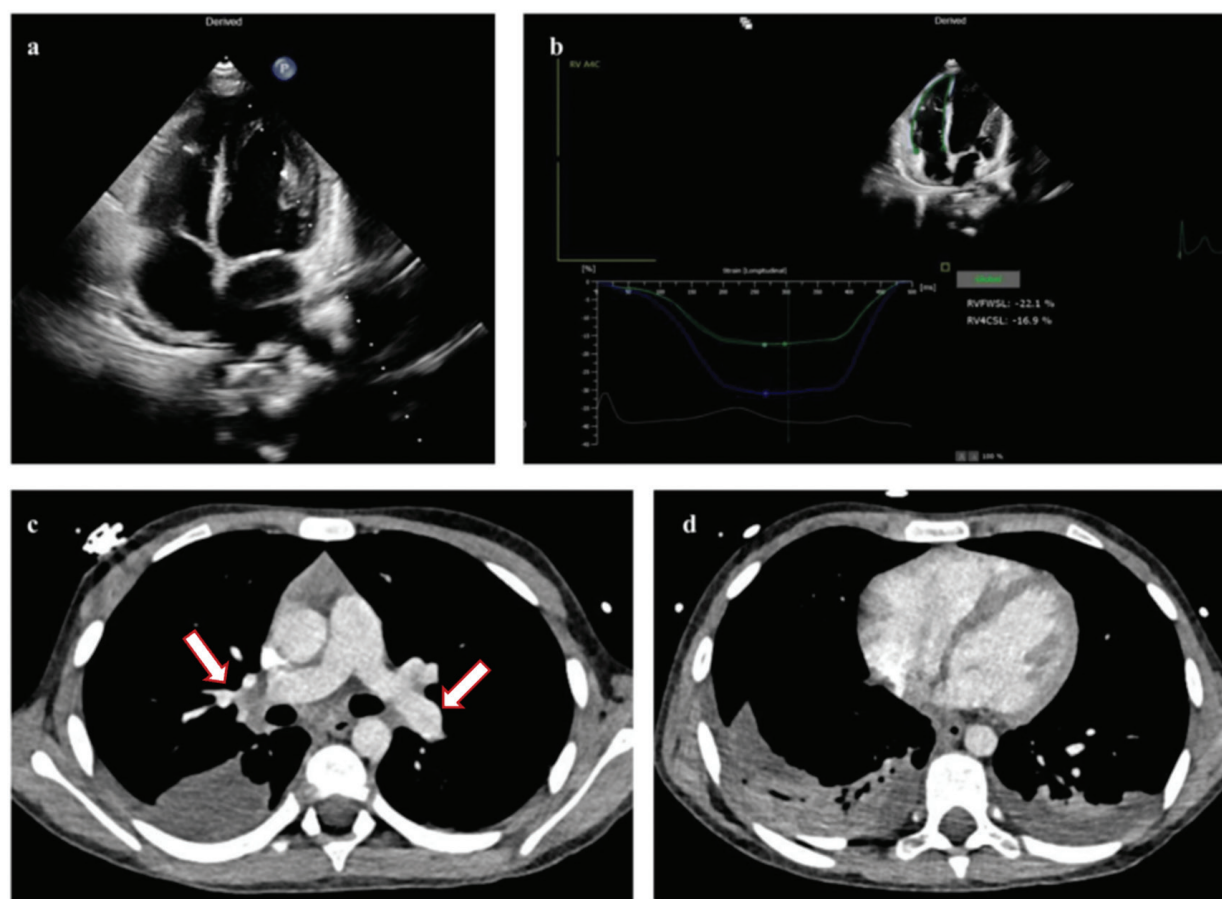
(a) Echocardiography showing regression of right heart chamber dilatation. (b) Improvement in right ventricular strain on follow-up imaging. (c, d) CT pulmonary angiography demonstrating a marked regression of bilateral massive pulmonary emboli extending into segmental branches (white arrows) and a reduction in right heart chamber size
